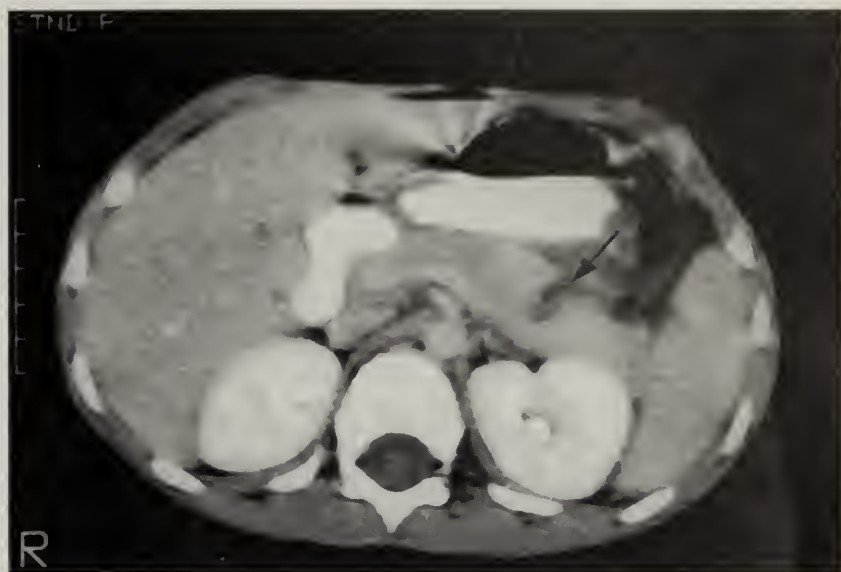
A computed tomogram following admission to the hospital. The study shows a probable pancreatic laceration (arrow).
